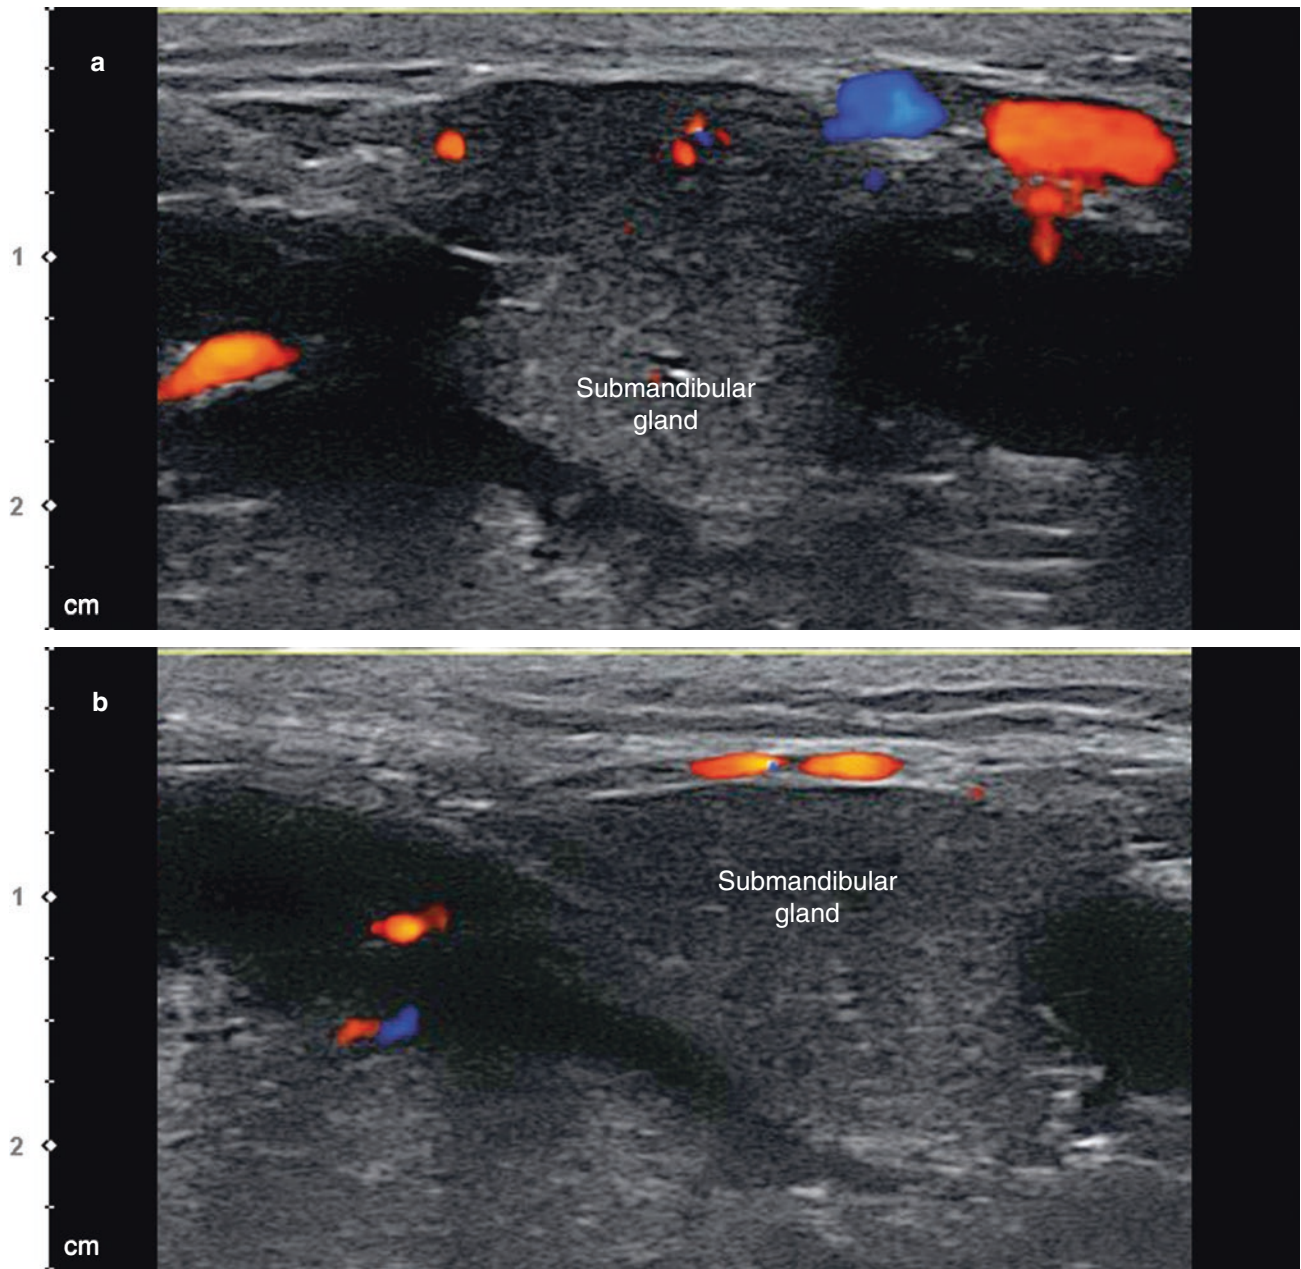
Ultrasonography of the submandibular gland in vicinity of the large vessels. (a, b) Doppler mode (transverse view, 15 MHz by linear transducer). (Published with kind permission of © Ji-Soo Kim 2020. All Rights Reserved)
